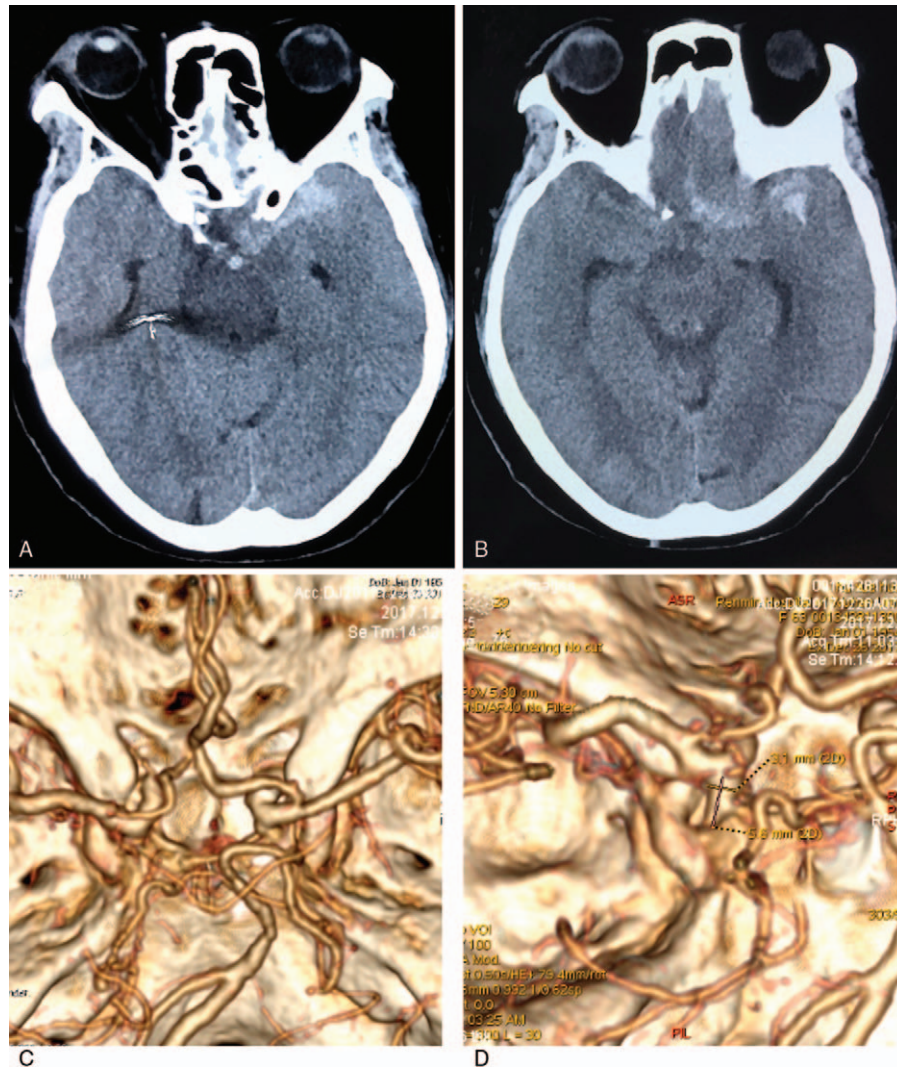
CT scan and CTA of the patient before the procedure. A, B. Head CT scan revealed a subarachnoid hemorrhage located mainly in the left ACP area. C, D. CTA indicated a posterior communicating artery aneurysm in the left side, and the ACP was closely related to the internal carotid artery and the aneurysm. CT=computed tomography, CTA=computed tomography angiography.
